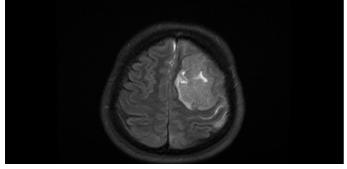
Diffusion-weighted magnetic resonance image taken at the time of presentation showing intracranial hematoma and a shift to the right
